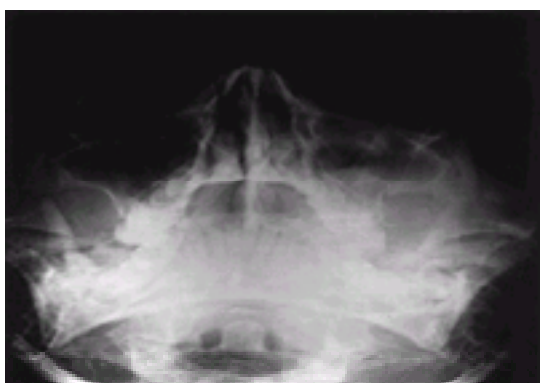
Reversed Water's view (mento-occipital position) provides the most information on the facial skeleton from single-view portable radiography; there is increased magnification of the facial bones due to the increased distance between the face and the film.
